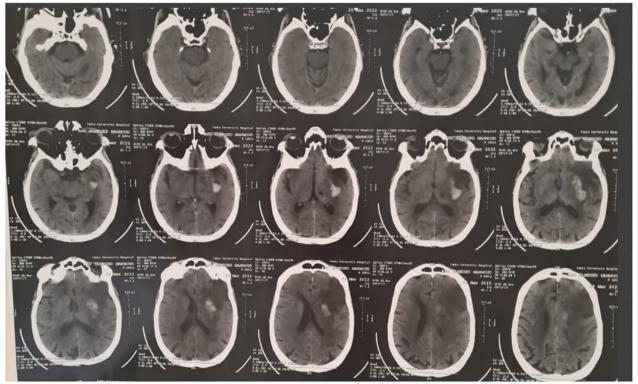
Male patient aged 63 years old. CT brain shows left partial middle cerebral artery. Infraction with (HI-2)
